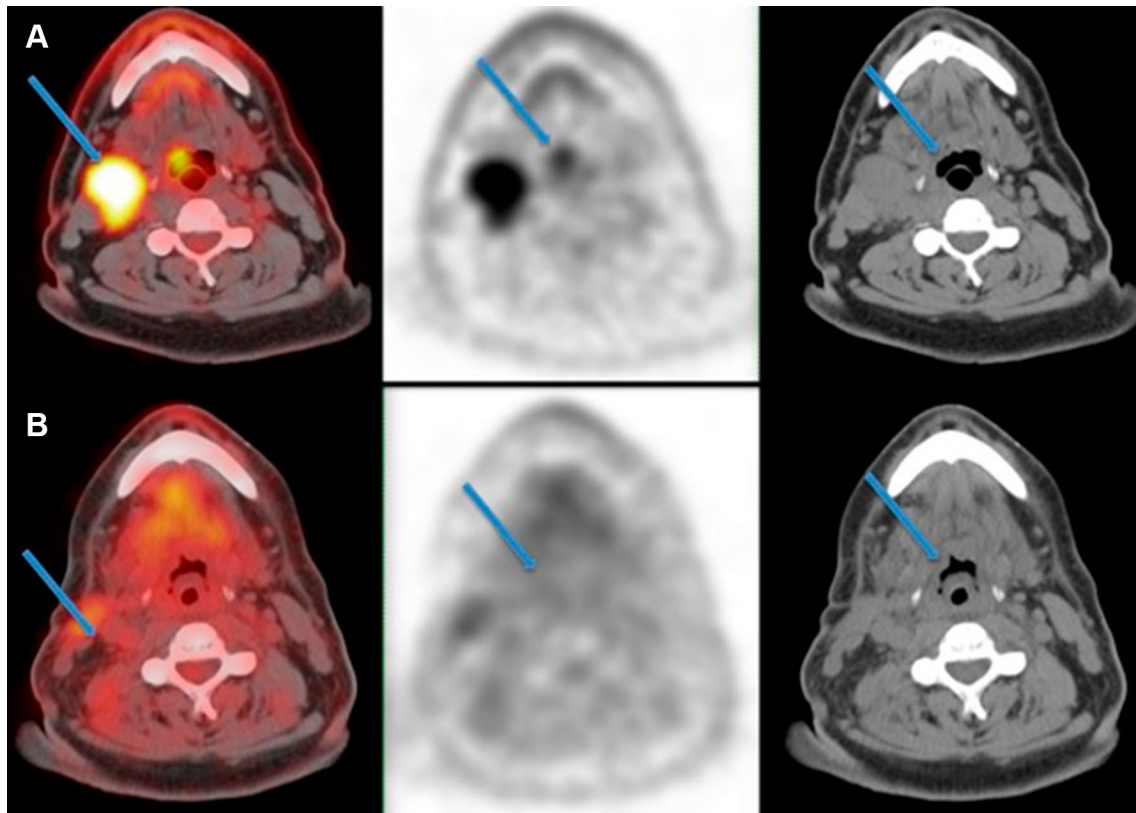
A 50-year-old male patient with squamous cell carcinoma in the right cervical lymph nodes with a hidden primary tumor. a PET-CT shows hypermetabolic lymph nodes and hypermetabolic focal
